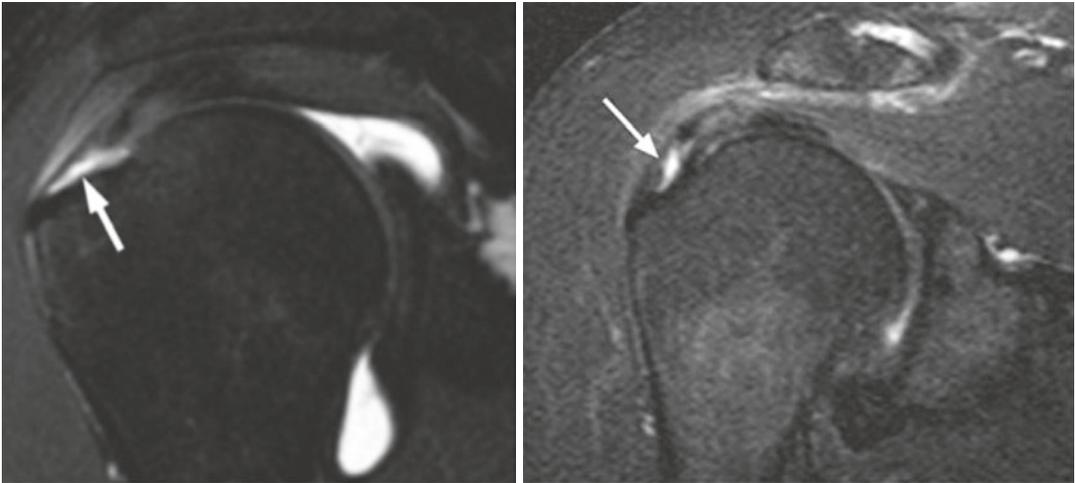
Coronal MRI View of articular rotator cuff tear
